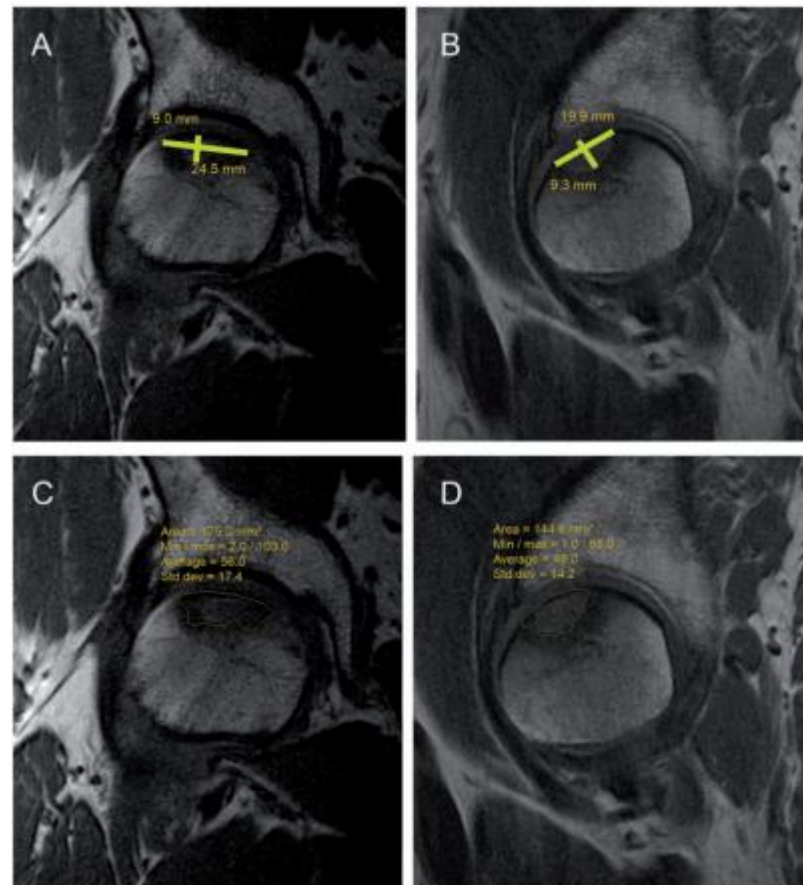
Maximal measures and area (yellow lines) of the avascular necrosis of the femoral head (AVNFH) were measured from coronal (a, c) and sagittal planes in T1-weighted images (b, d). The surrounding edema was not included.
